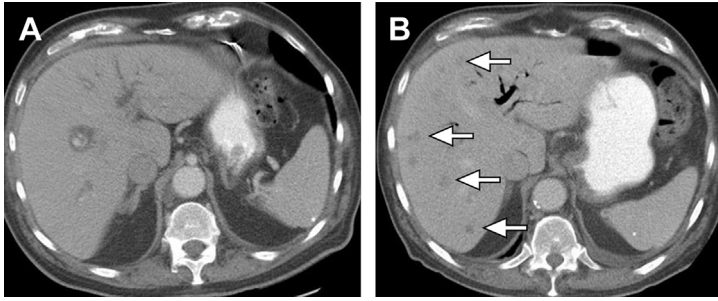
Metastasis from pancreatic adenocarcinoma. (A) Axial contrast-enhanced multidetector computed tomography (MDCT) image at the level of the liver obtained at the time of pancreatic adenocarcinoma diagnosis (tumor not shown) demonstrates no focal hepatic lesions. (B) Follow-up examination after 4 weeks demonstrates multiple hypodense lesions with enhancing rim in the liver (arrows) corresponding with interval development of metastatic deposit.
